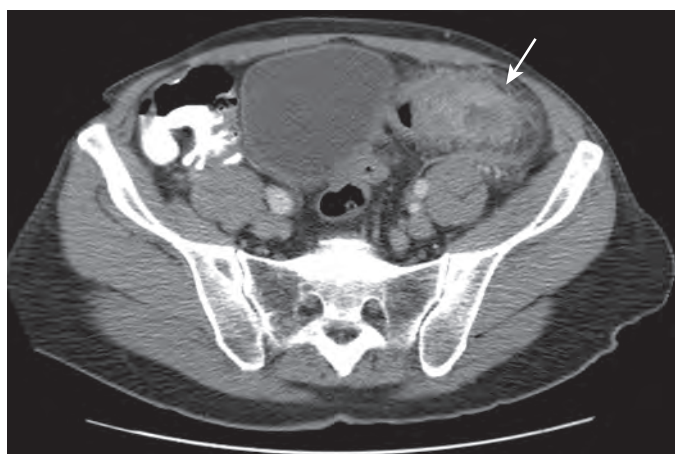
MDCT of diverticulitis: intramural abscess. Axial CT of the sigmoid colon shows mural thickening, pericolic inflammatory changes, and fascial thickening with the presence of an intramural abscess (arrow).
